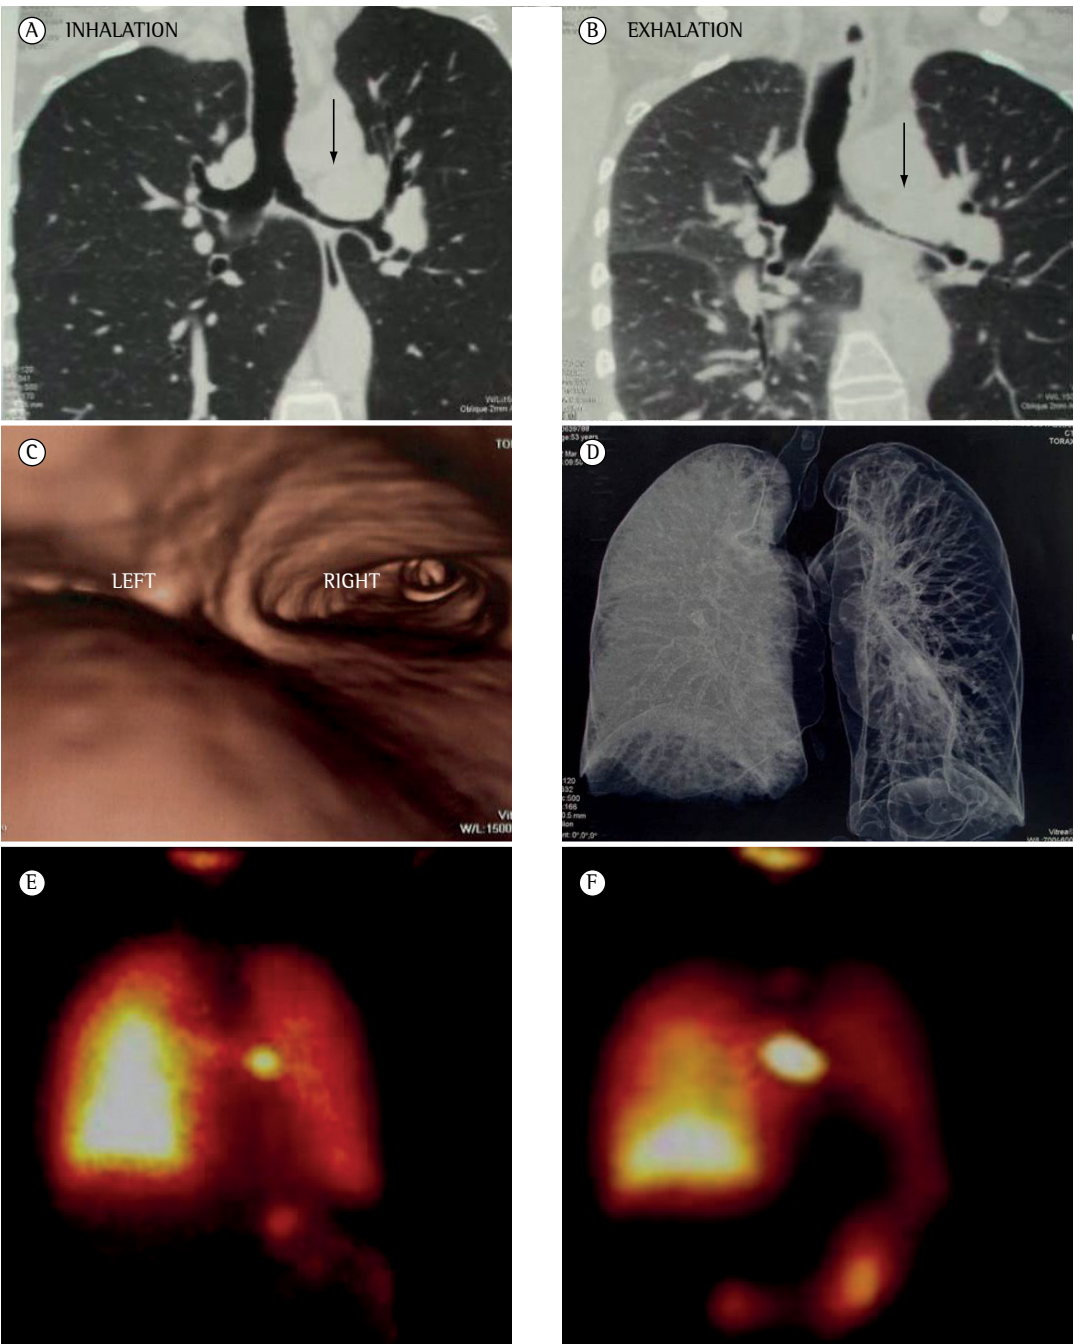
Coronal reconstruction of multidetector chest CT scans acquired during inhalation (A) and exhalation (B), endobronchial reconstruction of a multidetector chest CT scan (C), and volumetric reconstruction of a multidetector chest CT scan acquired at end-exhalation showing air trapping in the left lung (D); as well as radionuclide lung perfusion (E) and lung ventilation (F) images. The arrows show the site of the bronchial stenosis.
